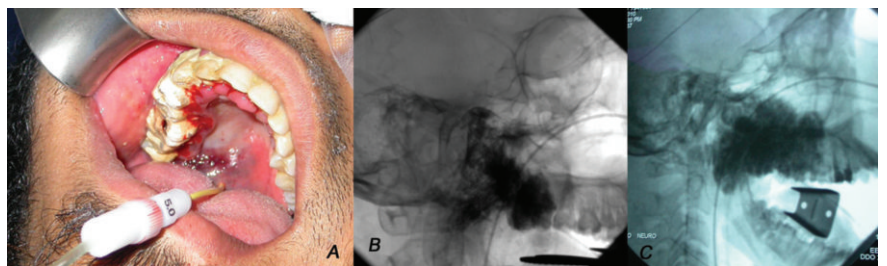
A) The catheter loaded with ethanol in place during injection; B) Contrast medium is injected into the lesion and an X-ray is taken to make sure that the catheter is within the lesion itself; C) An angiogram shows ethanol injection within the lesion.
